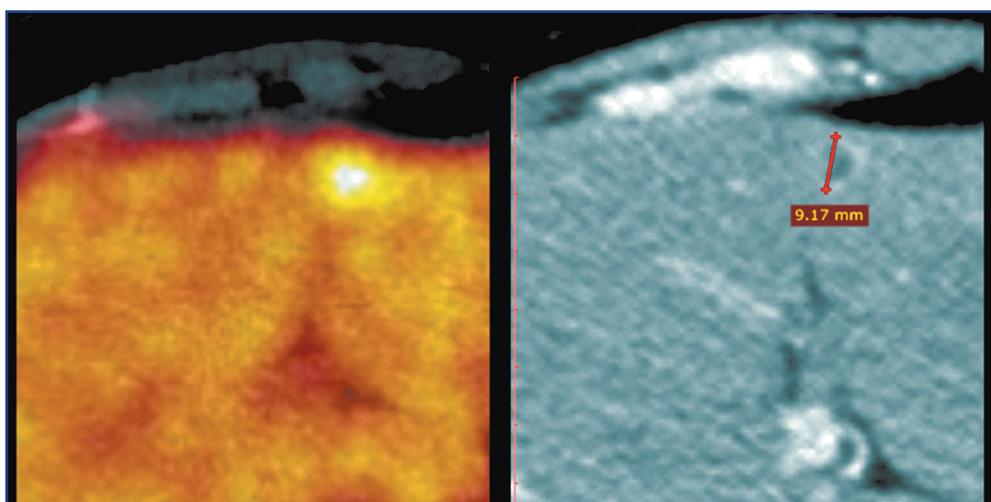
Thoracic Region CT from July 2018 in comparison with PET CT of March 2018. In the parenchyma S1 of the liver segment - metastatic site, partial regression of the process (40%).
